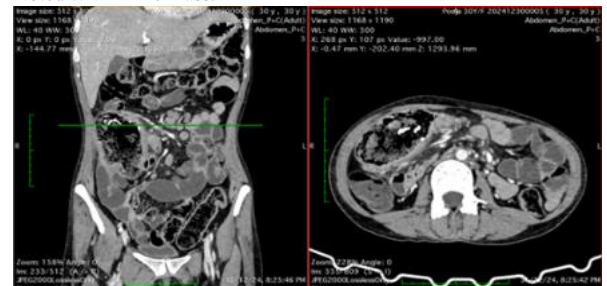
On POST-IV Contrast CT Images, Peripheral Enhancement Is Noted, Suggestive Of Inflammatory Changes In The Ileal Loop.
